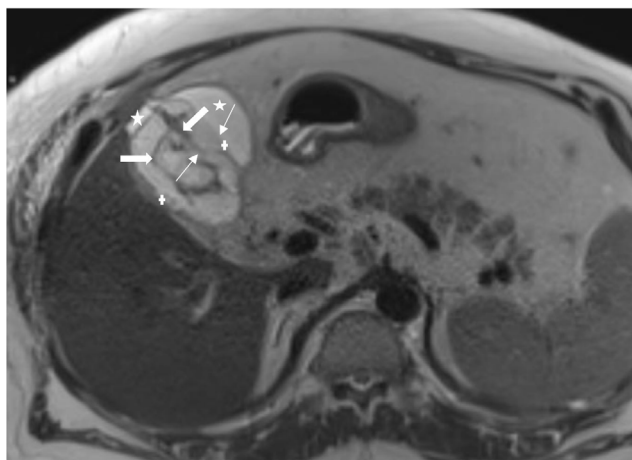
Delayed rupture of acute gangrenous cholecystitis. A 60-year-old male patient. He was admitted to the emergency room with the right upper quadrant pain during the pandemic period. Hydropic gallbladder showing gangrenous cholecystitis (distance between + signs), wall irregularities (thin arrows) are observed on axial T2-weighted MRI. Intraluminal intensities (thick arrows) represent exfoliated mucosa. It is also accompanied by pericholecystic free fluid (stars). The patient was treated by placing a separate drainage catheter in both the gallbladder lumen and the pericholecystic free fluid. He was discharged 5 days later
